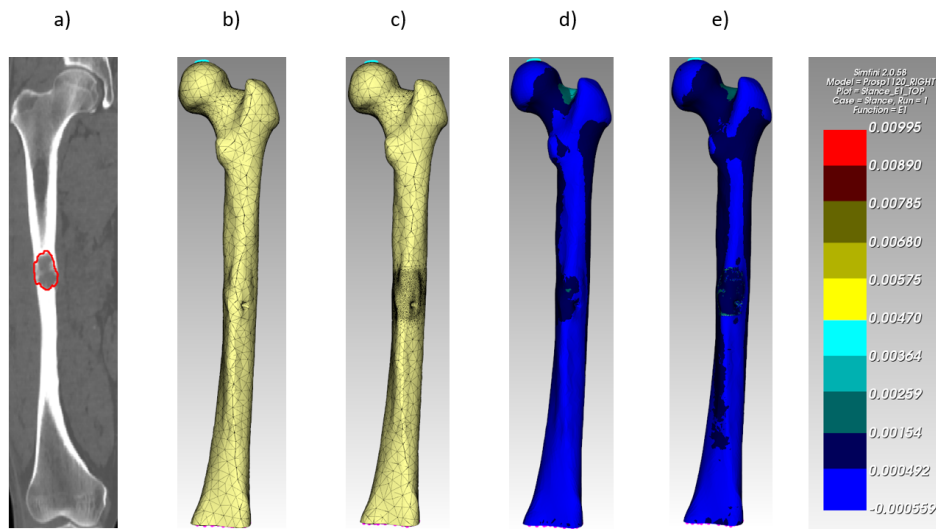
Prosp1120's right femur. (a) Displays the bone in the CT scan with delineated tumor around the middle shaft as observed by the analyst (marked by a red polygonal boundary). (b) + (c) Presents the p-mesh, with and without local refinement around the tumor in the middle shaft region. (d) shows the map of ϵ_1 principal strain on the original mesh while (e) shows it on the refined mesh. $E = 100MPa$ was used.
